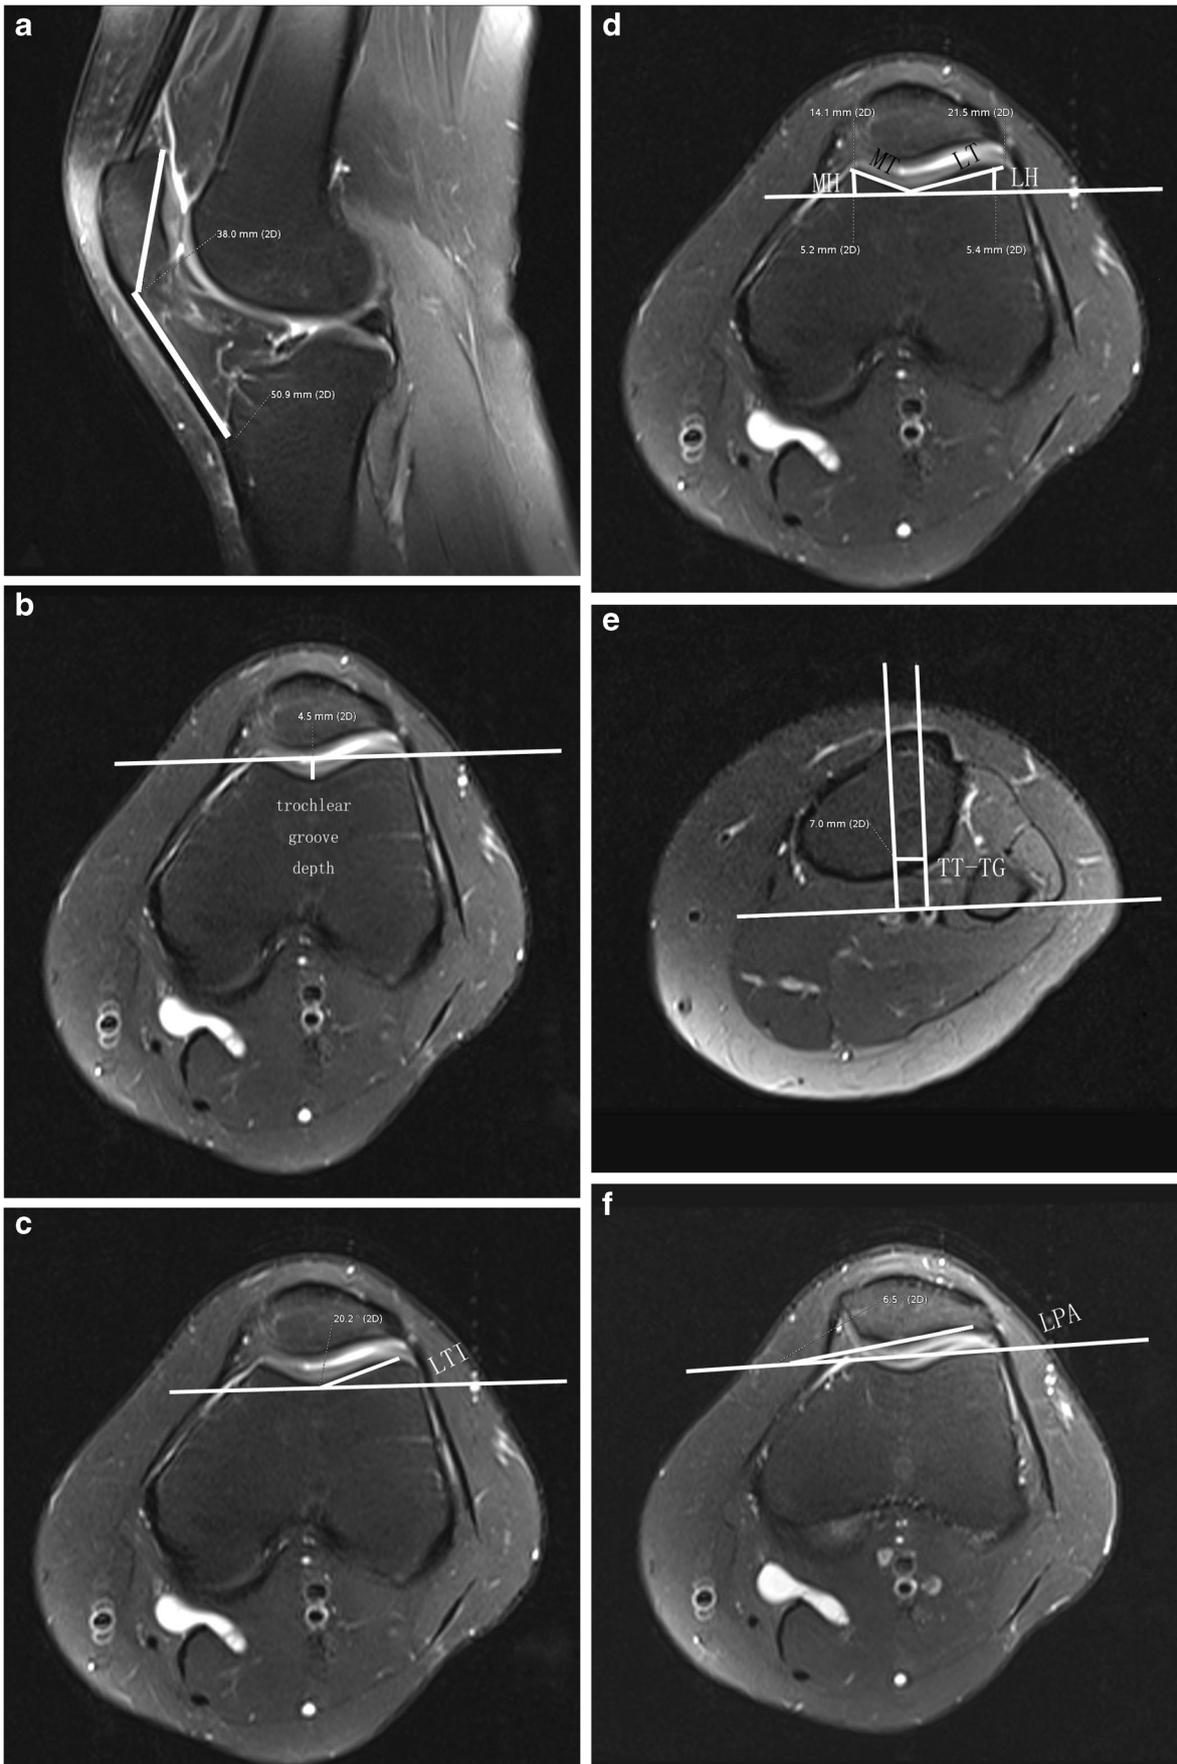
Methods for determining the seven quantitative patellofemoral parameters and calculating their relations using MRI. a MRI of the same patient as that in Fig. 1. The Insall–Salvati ratio was measured on the sagittal intermediate-weighted MRI and calculated as the patellar tendon length/maximum patellar length. b The trochlear groove depth was measured as the perpendicular distance between the deepest point of the trochlear groove and the line tangent to the anterior aspect of the femoral condyles. c The lateral trochlear inclination (*LTI*) was the angle between the bony lateral trochlea facet and the tangent of the posterior femoral condyles. d The medial trochlear/lateral trochlear (*MT/LT*) and medial trochlear/lateral trochlear (*MH/LH*) ratios were calculated from the length and height of the medial and lateral trochlea. e The tibial tuberosity–trochlear groove (*TT–GG*) distance was measured as the line drawn from the deepest point of the trochlear groove to the anterior-most point of the tibial tuberosity. f The lateral patellofemoral angle (*LPA*) was the angle between two lines: one line drawn along the lateral patellar facet and another line drawn along the anterior aspect of the femoral condyles
